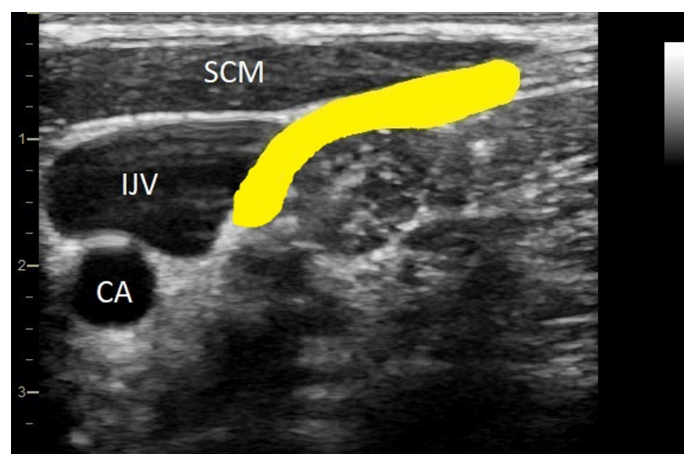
Transverse axis sonogram of the lateral side of the neck at the level of the fourth cervical vertebra. The yellow area shows the local anesthetic infiltrated area for ICPB. CA: carotid artery; IJV: internal jugular vein; SCM: sternocleidomastoid muscle.
